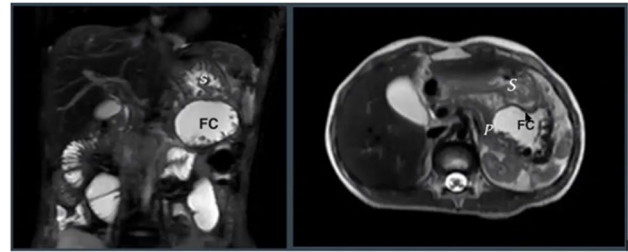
Upper Abdomen MRI. FC-Fluid Collection, P-pancreas, S-stomach
